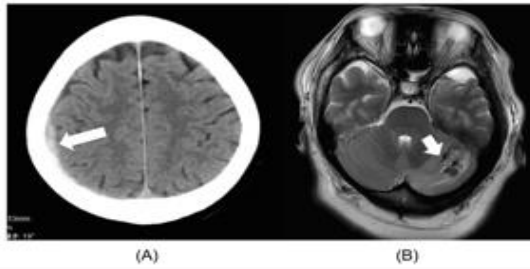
Remote intracranial hemorrhage in the cerebrum and cerebellum. A) Brain computed tomogram of a 75-year-old male with ossification of the ligamentum flavum at C7-T1. Small, subdural hemorrhage is detected in the right cerebrum (arrow). B) Brain magnetic resonance image of a 48-year-old female with ossification of the posterior longitudinal ligament in the thoracic spine. Intraparenchymal bleeding is detected in the left cerebellar hemisphere (arrow).
